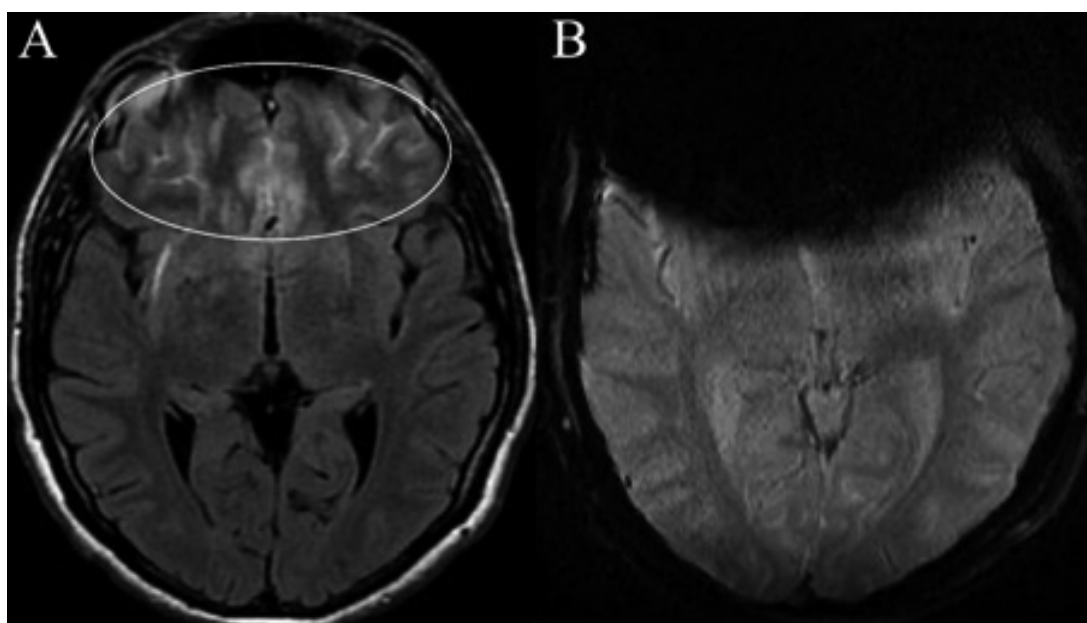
Pseudo-SAH appearance due to braces. A, In FLAIR image, hyperintensities in the bifrontal sulci (ellipse) are seen. B, There is anterior cranial wide magnetic susceptibility artifact in SWI images.
